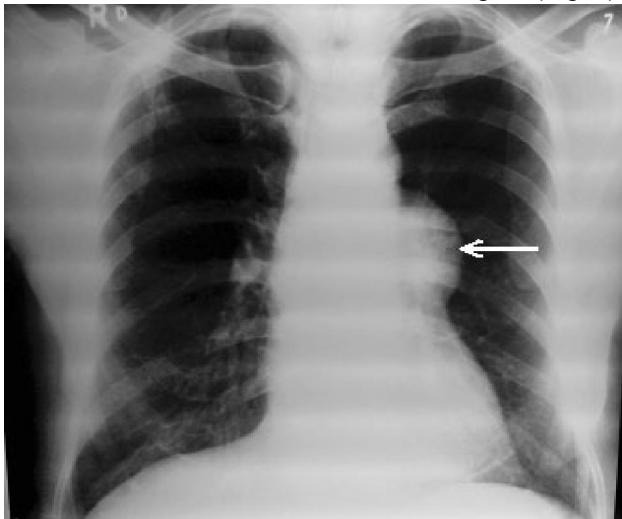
X-ray chest PA view showing a well-defined area in left hilar region (arrow).
